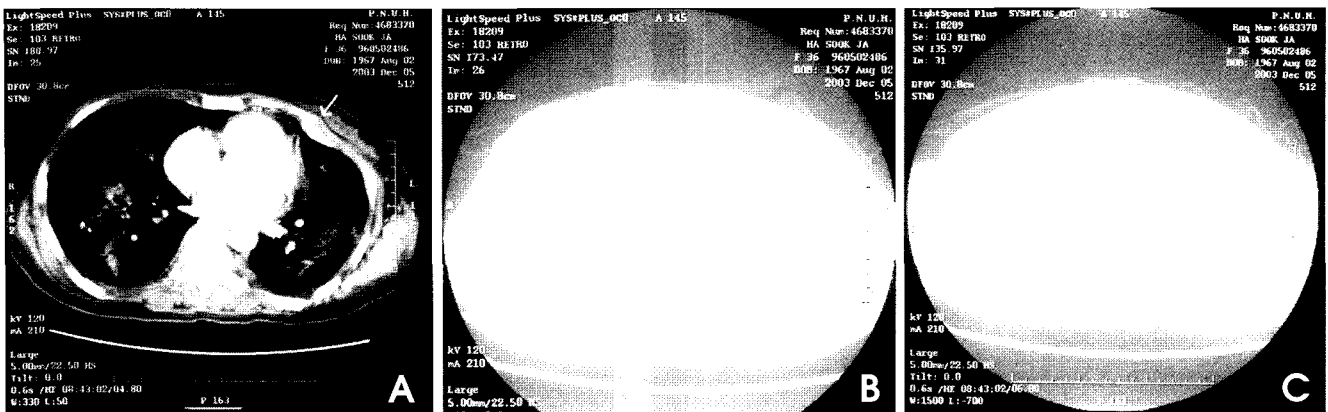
A. Computed tomography of chest at mediastinal setting showed multiple osteolytic lesions and pathologic fracture of rib (white arrow) consistent with bone metastasis. B. Computed tomography of chest at lung setting showed multiple patchy or diffuse areas of ground glass opacity and focal consolidation on both lungs. C. Computed tomography of chest at lung setting showed small pleural effusion on both lungs. Opportunistic pulmonary infection such as pneumocystis carinii pneumonia or mixed viral infection was suspected.
